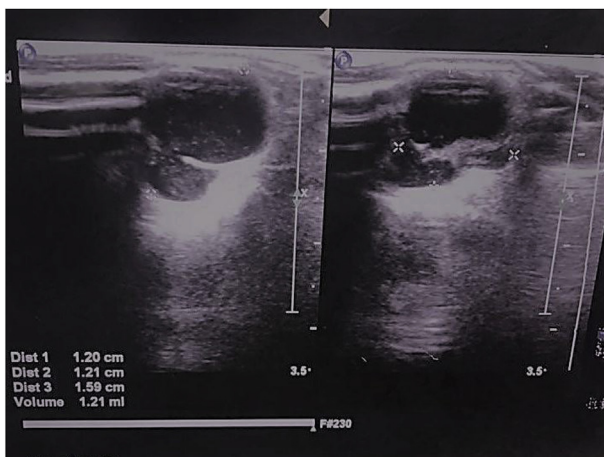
The Ultrasound of the ganglion showing volume calculation. The largest measurement in three directions were used to calculate the volume. The cyst in the figure is septated with volume of 1.2 ml.
